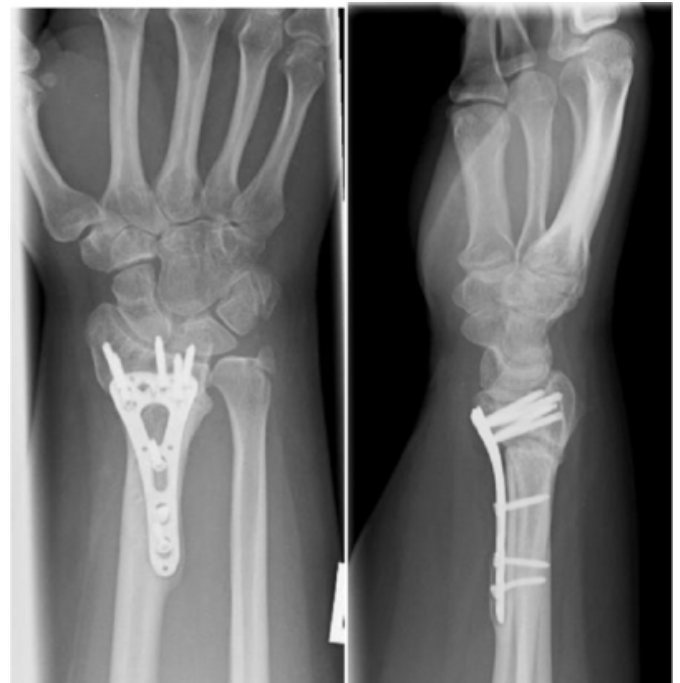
radiographs of the right wrist 5 months following revision with volar locking plate and bone grafting
